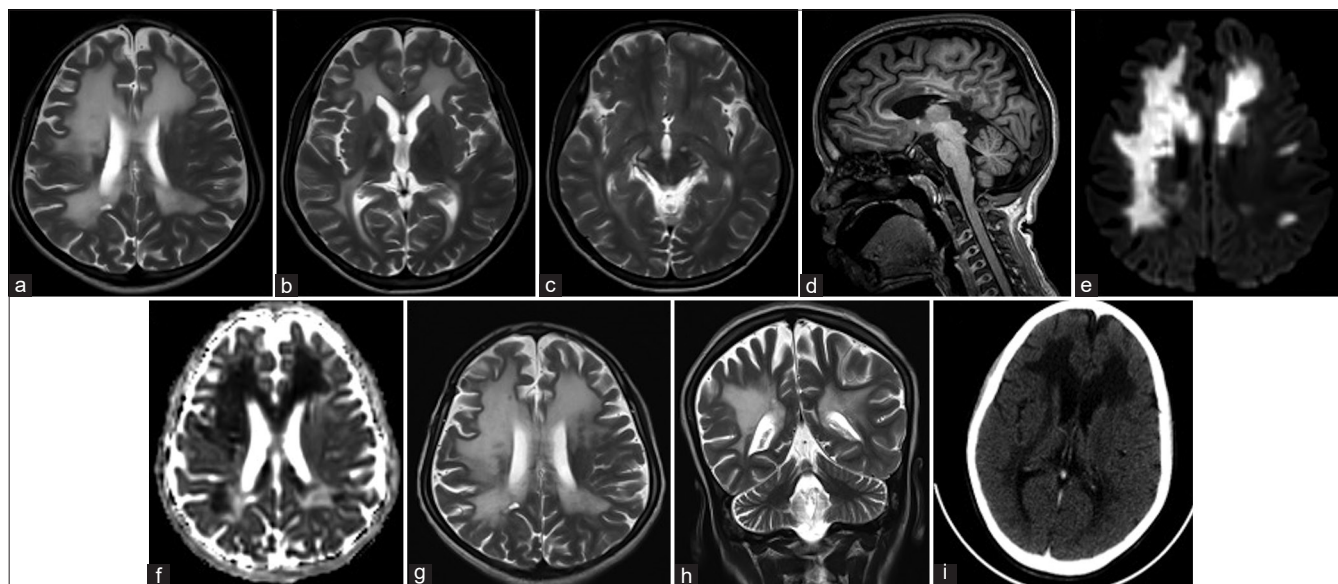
MRI Brain done at 12 years of age (a-f) (a) - Asymmetric T2 hyperintensity in frontal, parietal, occipital, lobar white matter, also involving genu, anterior body, posterior body and splenium of corpus callosum; (b and c) - Involvement of corticospinal tract along posterior limb of internal capsule to medulla; (d) - Cerebral and callosal atrophy; (e and f) - Diffuse Diffusion-weighted imaging restriction in involved white matter; MRI Brain done at 12 years 6 months of age (g and h) worsening with subcortical U fibre involvement; (i) - CT scan confirming the findings of MRI
